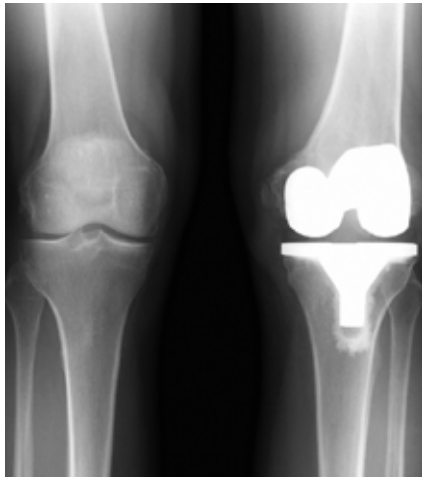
Preoperative standing AP radiograph. Note well-fixed TKA implants. The patient had knee range of 0-130 degrees, but had a persistently large knee effusion and chronic pain.
